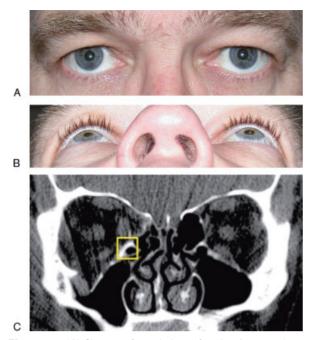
(A) Close-up frontal view of patient's eyes showing no signs of posttraumatic enophthalmos 6 months following the injury despite having a large right-sided orbital floor and medial wall fracture (Fig. 5C). The patient had no surgery. (B) Close-up worm's-eye view of same patient as seen in Fig. 5A showing no evidence of posttraumatic enophthalmos following large orbital fracture on right side. The patient had no surgery. (C) Coronal computed tomography scan of same patient as seen in Figs. 5A and 5B performed acutely after right-sided orbital floor and medial wall fractures. Total fracture area measures 6.30 cm². There is minimal rounding seen in the inferior rectus muscle possibly due to either minimal soft tissue herniation or an intact medial orbital buttress (uncinate process of maxilla), which is outlined in the yellow square. Despite having a large fracture, this patient did not develop posttraumatic enophthalmos.
